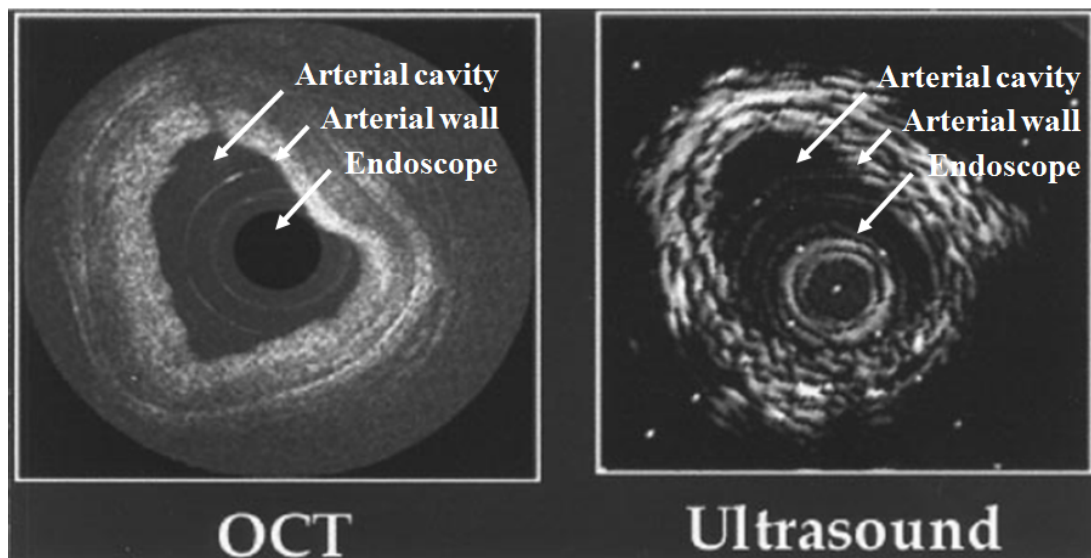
Comparison of Ultrasound and OCT imaging of the coronary artery with intravascular endoscope systems. Images reused with permission from (67) © [1999] IEEE.
